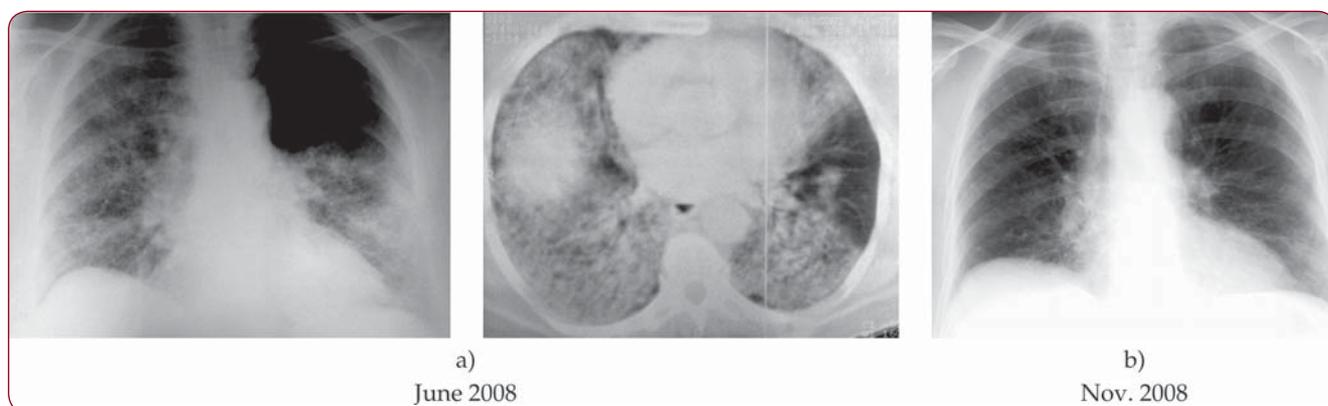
Case with ANCA associated vasculitides. a) Initial chest radiograph and CT scan showing extensive right and less extensive left alveolar infiltrates and b) 5 month later images demonstrating remarkable clearing of intrapulmonary hemorrhagic infiltrates
